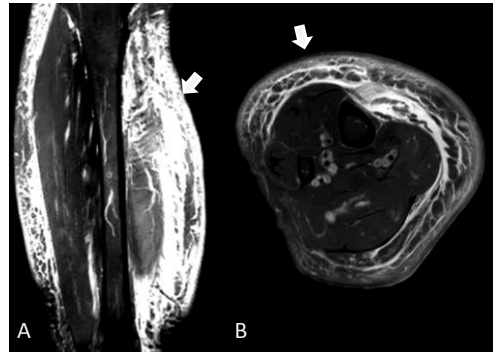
In right lower leg, Sagittal fat-suppressed T2-weighted MRI (A) Axial fat-suppressed T2-weighted MRI (B) showed subcutaneous edema with honeycomb pattern (arrows).
